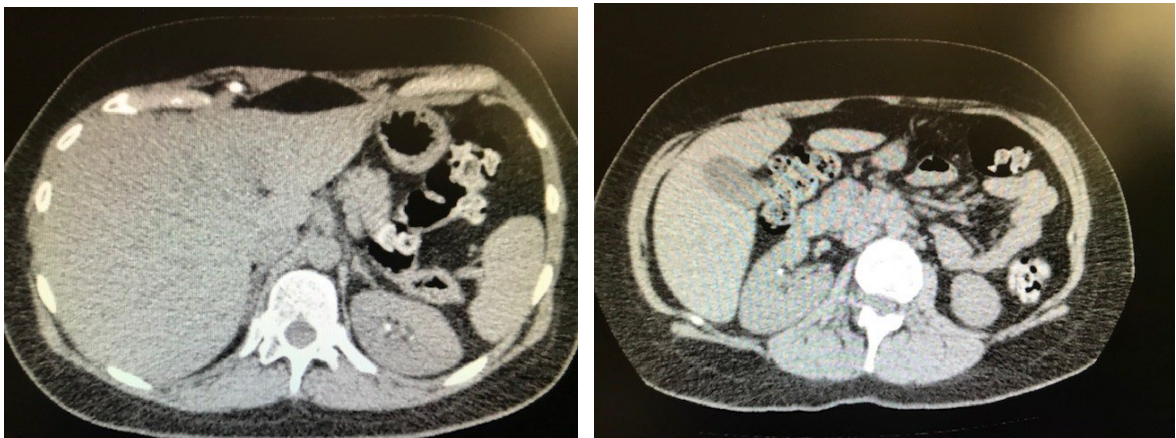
AP CT with a radiopaque image in the left kidney of about 15 mm suggesting kidney stone. Presence of multiple radiopaque images <10 mm in the right kidney.
